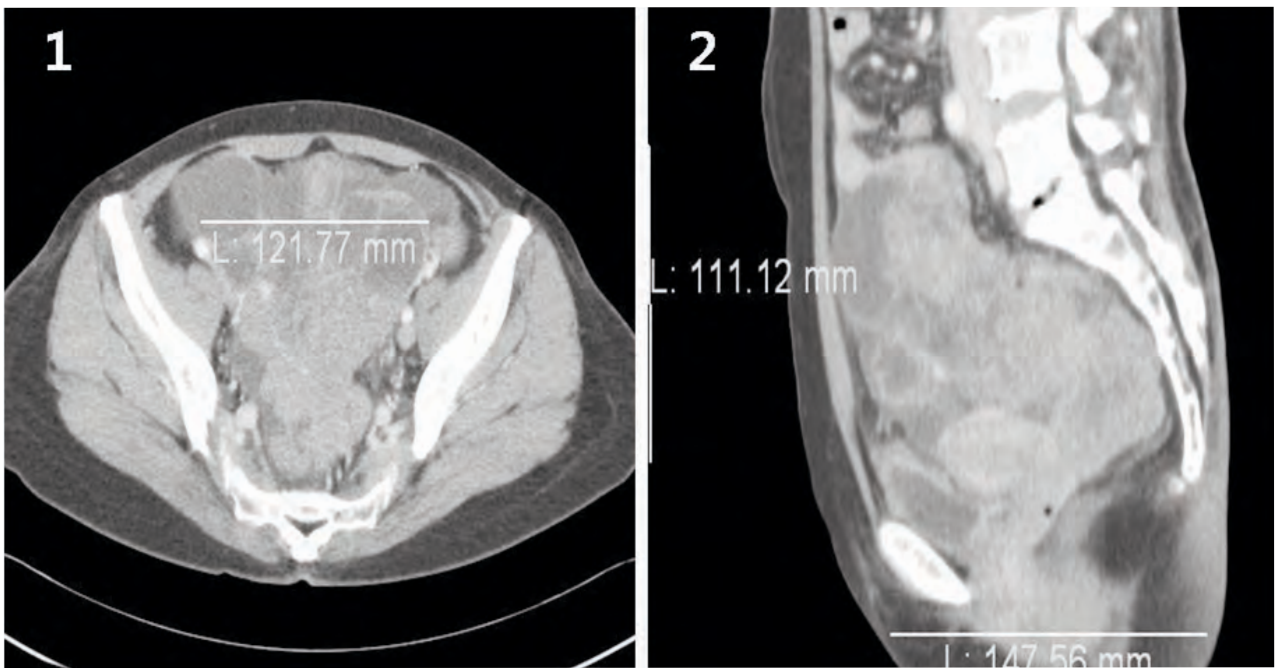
Pelvic CT scan showed that the mass extended to the pelvic side wall (Figure 1-1) and occupied the entire cul-de sac (Figure 1-2).
